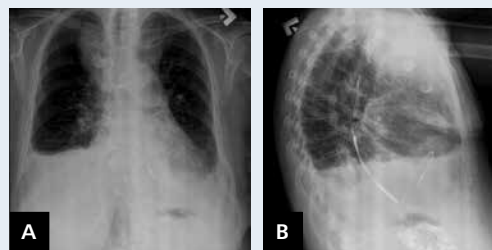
Chest X-ray; A. Posterior-anterior view. Apart from widened mediastinal silhouette, fluid accumulation in the right pleural cavity can be observed. The pacemaker electrode tip is positioned on the interventricular septum; B. Side view
